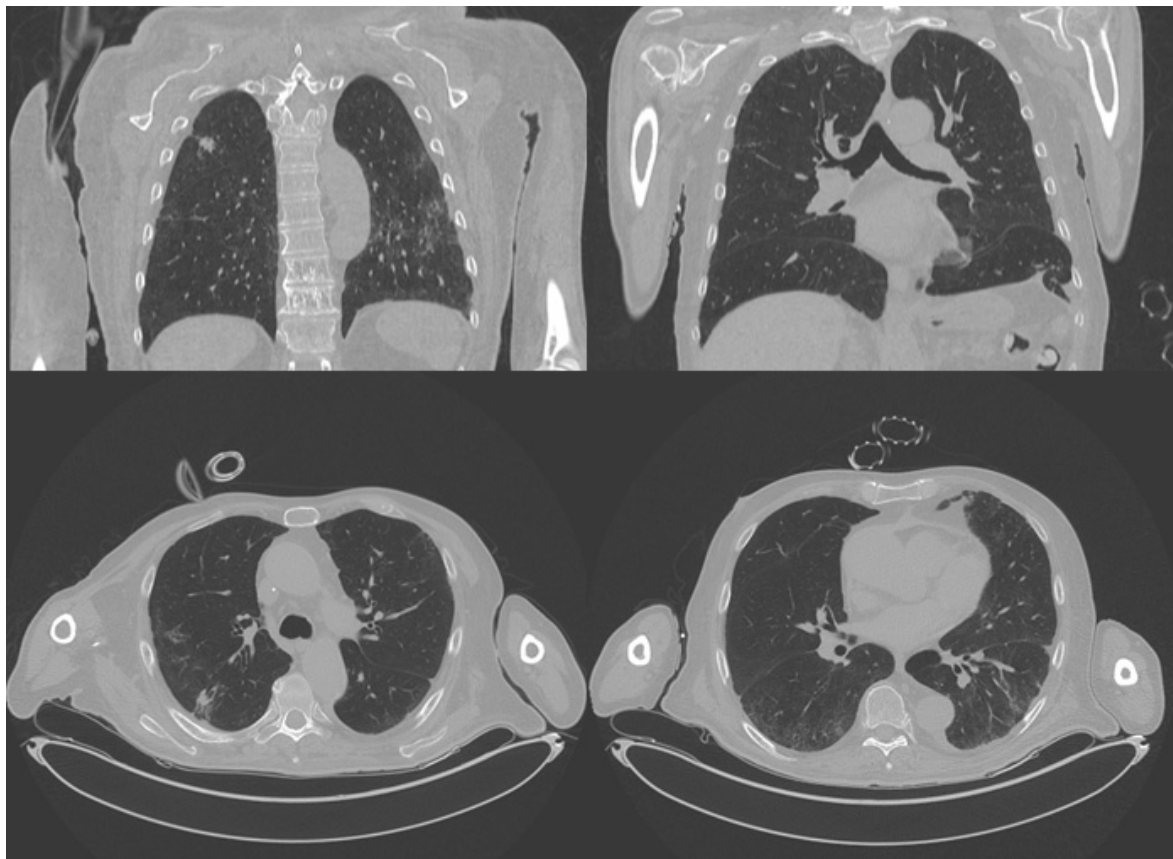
HRCT scan images (axial and coronal): peripheral ground-glass disease of both lungs with moderate amount of pleural effusion of the left lung with focal consolidations in the lower and upper lobe of the right lung.
